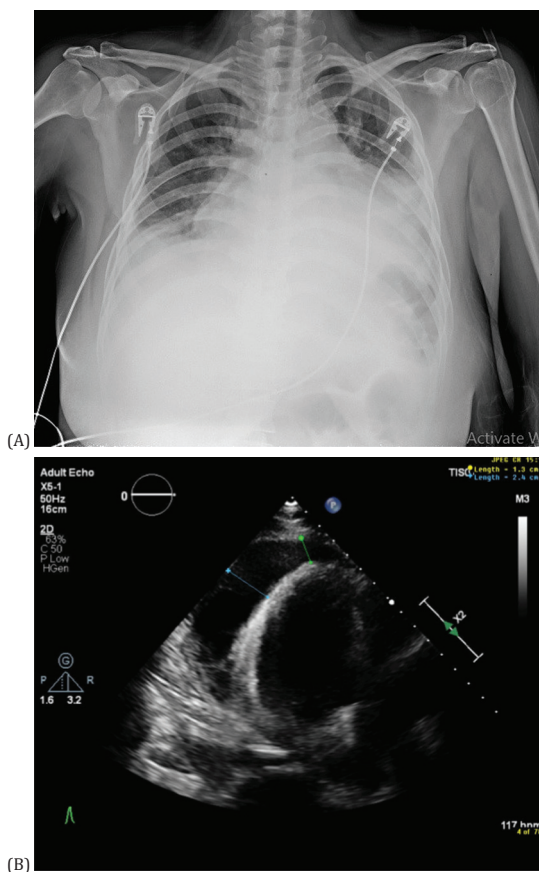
(A) The chest X-RAY revealed cardiomegaly with bilateral pleural effusion. (B) Echocardiogram confirmed accumulated pericardial effusion, measuring about 2.6 cm at posterior wall.
